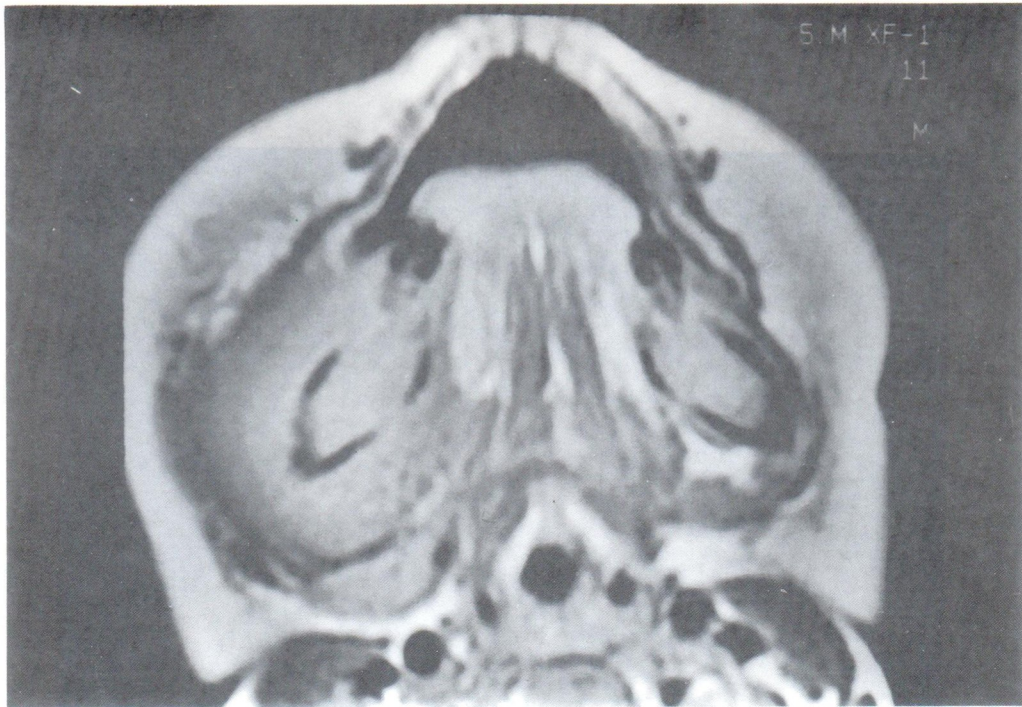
Axial T1-weighted MRI demonstrates the right masseter muscle splayed around a soft tissue mass with no abnormal signal seen of the medulla of the mandibular body.
